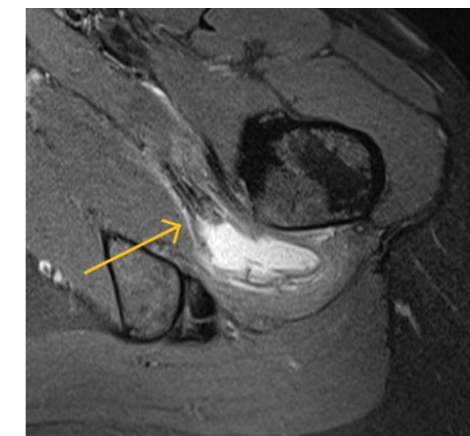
MRI axial fat suppressed PD scan. Acute intramuscular haematoma related to a myotendinous junction injury of quadratus femoris.
